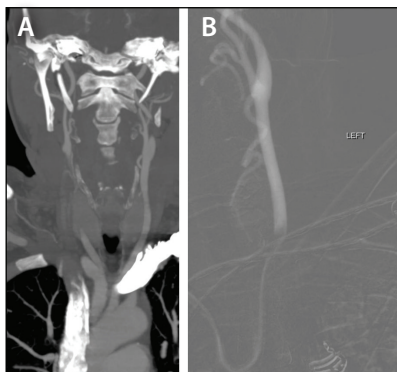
Coronal CTA image demonstrating a type III aortic arch configuration (A). TRA permitted catheterization of the left CCA with relative ease (B).
